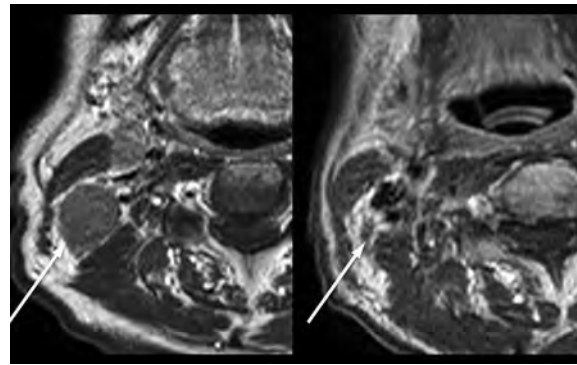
Axial T1 W post contrast MRI showing right nodal metastases pretreatment (*left*) and 6 months post chemoradiotherapy (*right*). An enlarged right level II node (*arrow*) has reduced significantly in size following treatment although there is a small amount of residual soft tissue remaining. This was believed to represent a post treatment scar and there has been no regional recurrence as of 3 years post treatment
